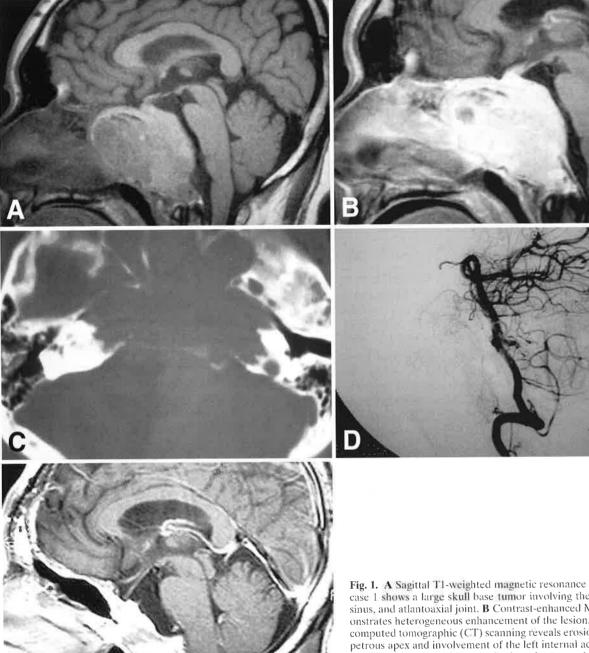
A Sagittal T1-weighted magnetic resonance (MR) imaging of case 1 shows a large skull base tumor involving the clivus, sphenoid sinus, and atlantoaxial joint. B Contrast-enhanced MR imaging demonstrates heterogeneous enhancement of the lesion. C Bone-window computed tomographic (CT) scanning reveals erosion of the bilateral petrous apex and involvement of the left internal acoustic meatus. D Lateral view of the left vertebral angiogram exhibits the feeding arteries. E Contrast-enhanced MR imaging 24 months after operation demonstrates successful tumor control
